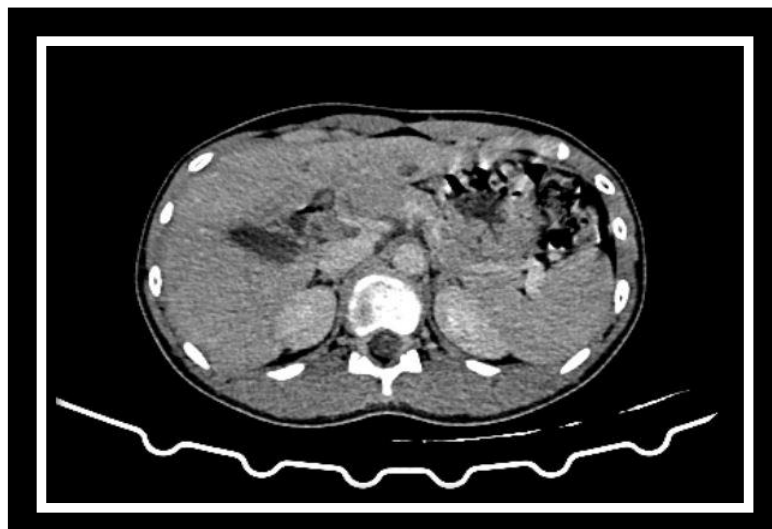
Axial CT image in venous phase showing small collateral vessel arising from the common trunk just before draining into IVC.
